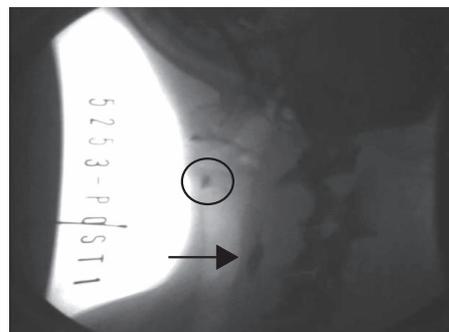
Typical X-ray image of aspiration of marker into the trachea. As the arrow shows, a bolus exhibits marker congestion in the upper esophagus. Note that the marker introduced into the pharynx was detected not in the esophagus but in the trachea as bolus shown in the image by a circle shows.
